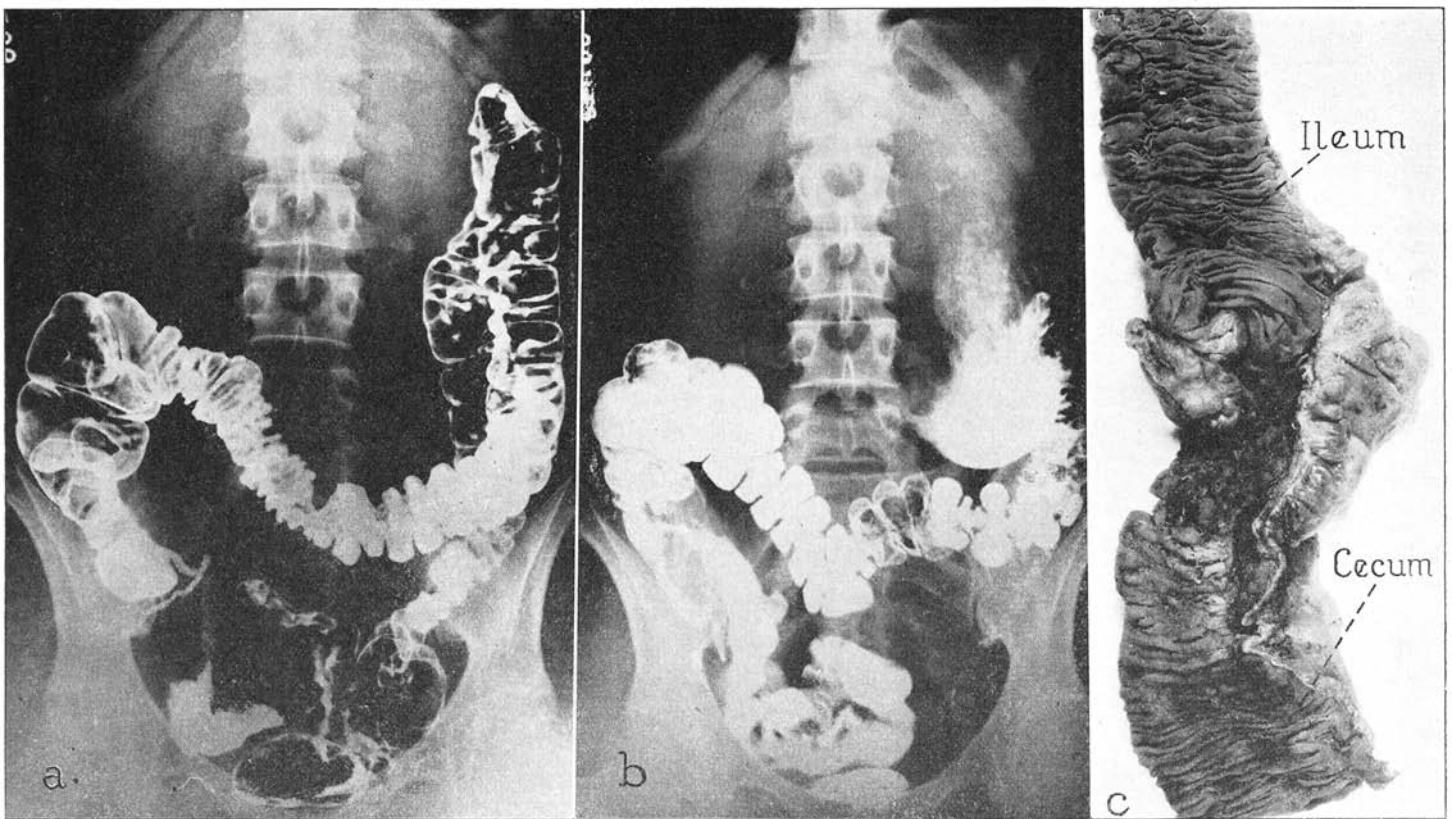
a*, "combined" roentgen method: deformity of cecum and terminal portion of ileum. The appendix is rendered visible. *b*, Opaque meal occupying terminal portion of ileum and proximal portion of colon. Deformity of terminal portion of ileum and cecum, without hypermotility. *c*, Thickened, inflamed ileum, with many deep, irregular ulcers.
